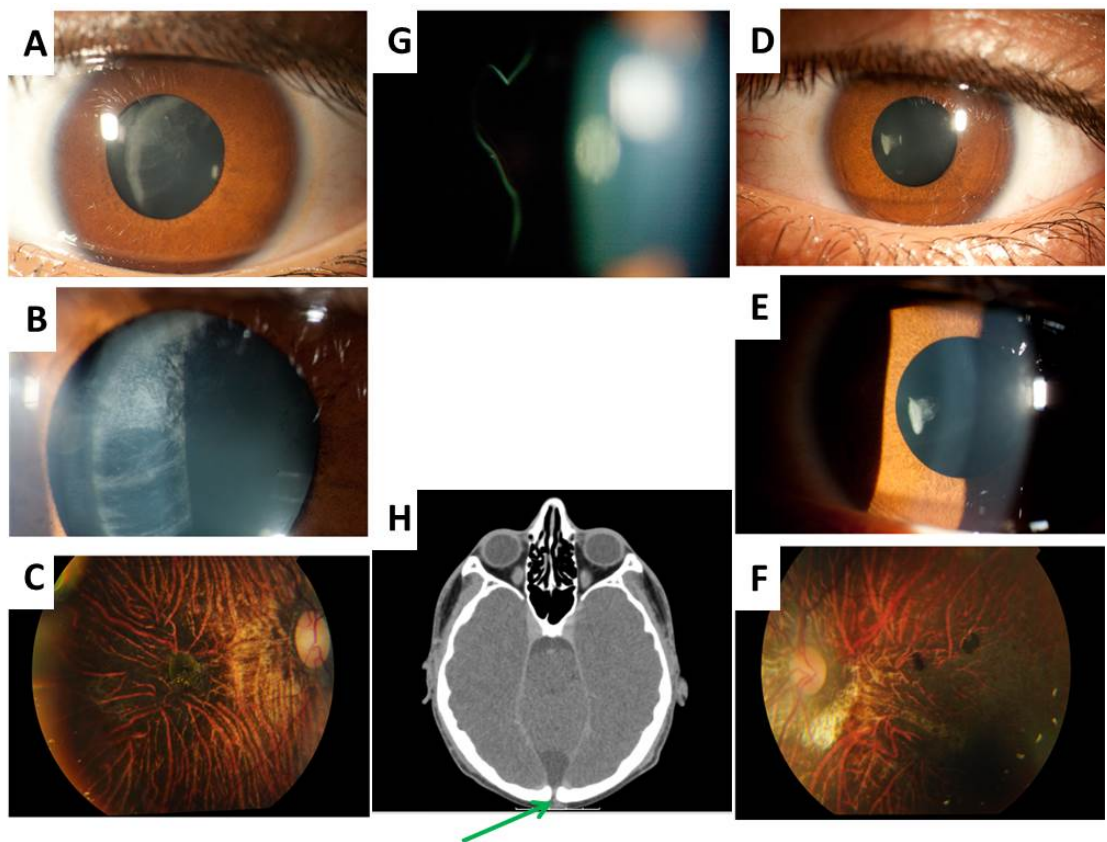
Clinical features of CII:1. A&D: Right & Left anterior segment demonstrating featureless iris. B&E: Right and Left characteristic lenticular opacities. C&F: Right and Left fundal photograph. G: Fibrillar vitreous. H: Axial CT demonstrating occipital defect (arrow).
